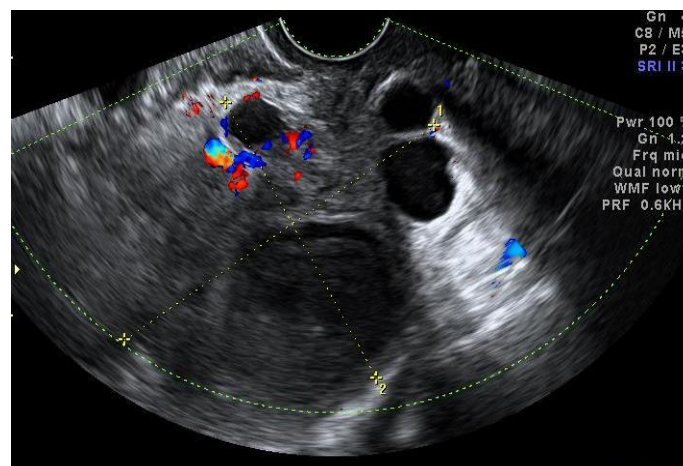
Ultrasound picture of a multicystic mass with thick and rich vascularised walls, containing heterogenic fluid
